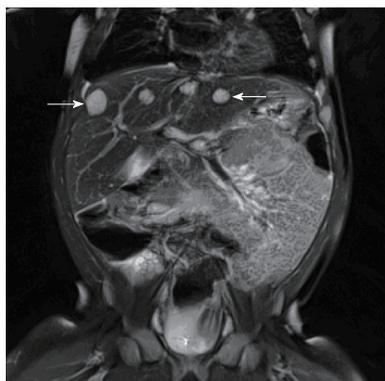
Multiple infantile hepatic hemangiomas. Coronal T2 weighted MRI image through the upper abdomen in a 5-mo-old girl depicts multiple well-defined, T2 hyperintense masses in the liver (arrows). This was consistent with multifocal infantile hepatic hemangiomas. MRI: Magnetic resonance imaging.
